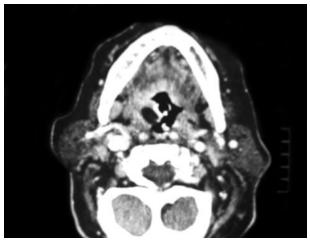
The hypodense submucosal mass seen on CT.
